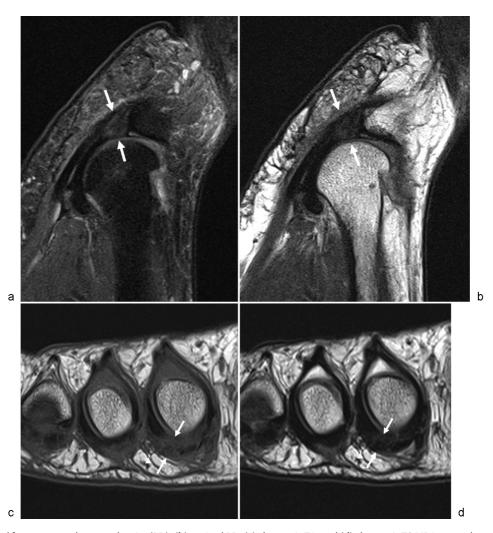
(a) Sagittal fat-suppressed proton-density (PD), (b) sagittal PD, (c) short-axis T1, and (d) short-axis T2 MR images demonstrating myxoid degeneration of the lateral plantar plate of the second MTP joint toward the proximal phalangeal insertion, without tear, (arrows). Note the normal neurovascular bundle in the second web space on short-axis images (arrowheads).
